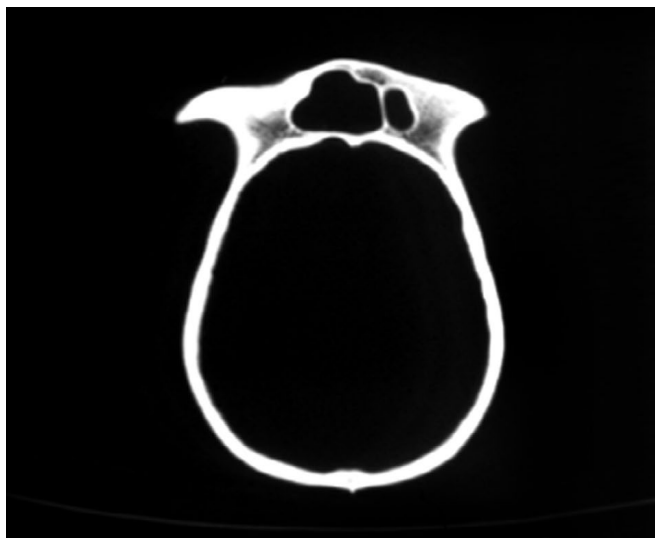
An axial computed tomography scan showing the asymmetric frontal sinuses of the chimpanzee. This individual exhibits an enlarged right frontal sinus.
